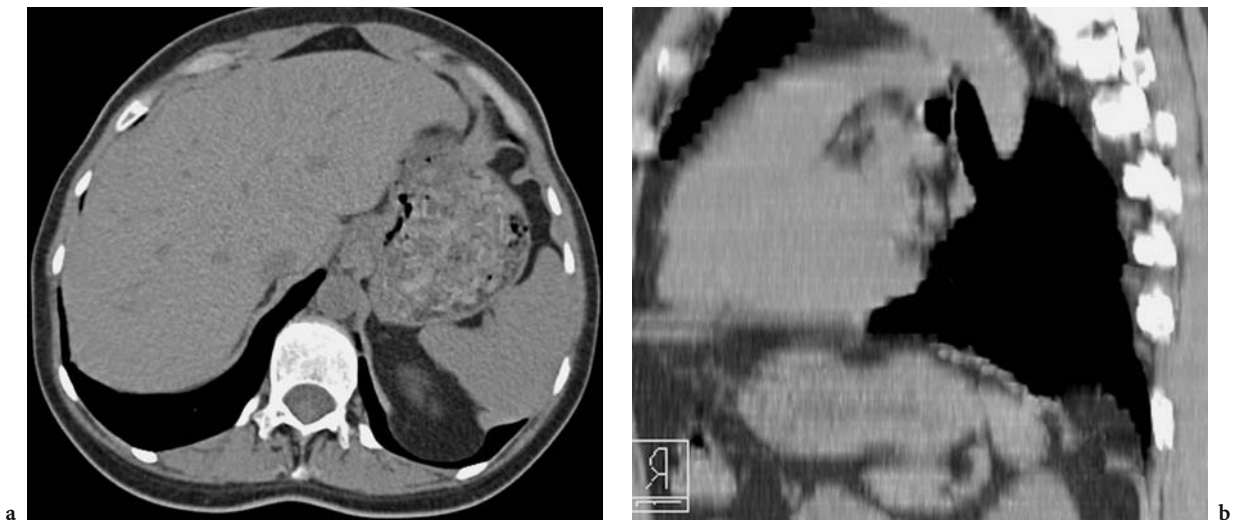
A MDCT of the diaphragm a axial and b sagittal reconstructions. Small Bochdalek hernia presenting as a fatty mass in continuity with subdiaphragmatic structures through a diaphragmatic defect presenting as a discontinuity of the soft tissue line of the diaphragm. The CT protocol: acquisition 4×2.5 mm; pitch 1.38; slice thickness for axial slice and sagittal reformation 5 mm
